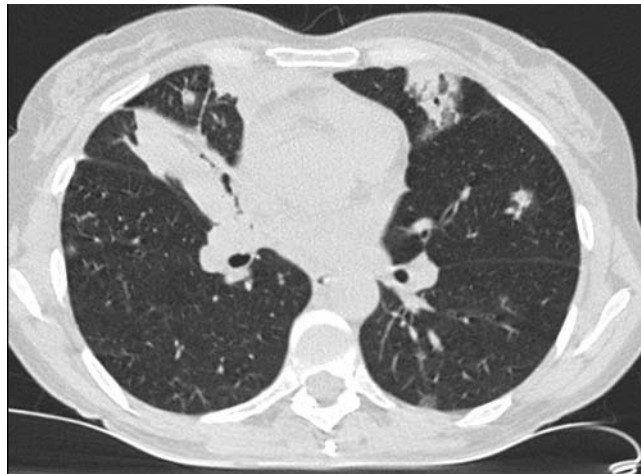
High resolution computed tomography image of a patient with sero-positive rheumatoid arthritis and biopsy-proven organizing pneumonia. There are areas of well-demarcated consolidation; note also the presence of bronchiectasis, a common CT feature of rheumatoid arthritis.
